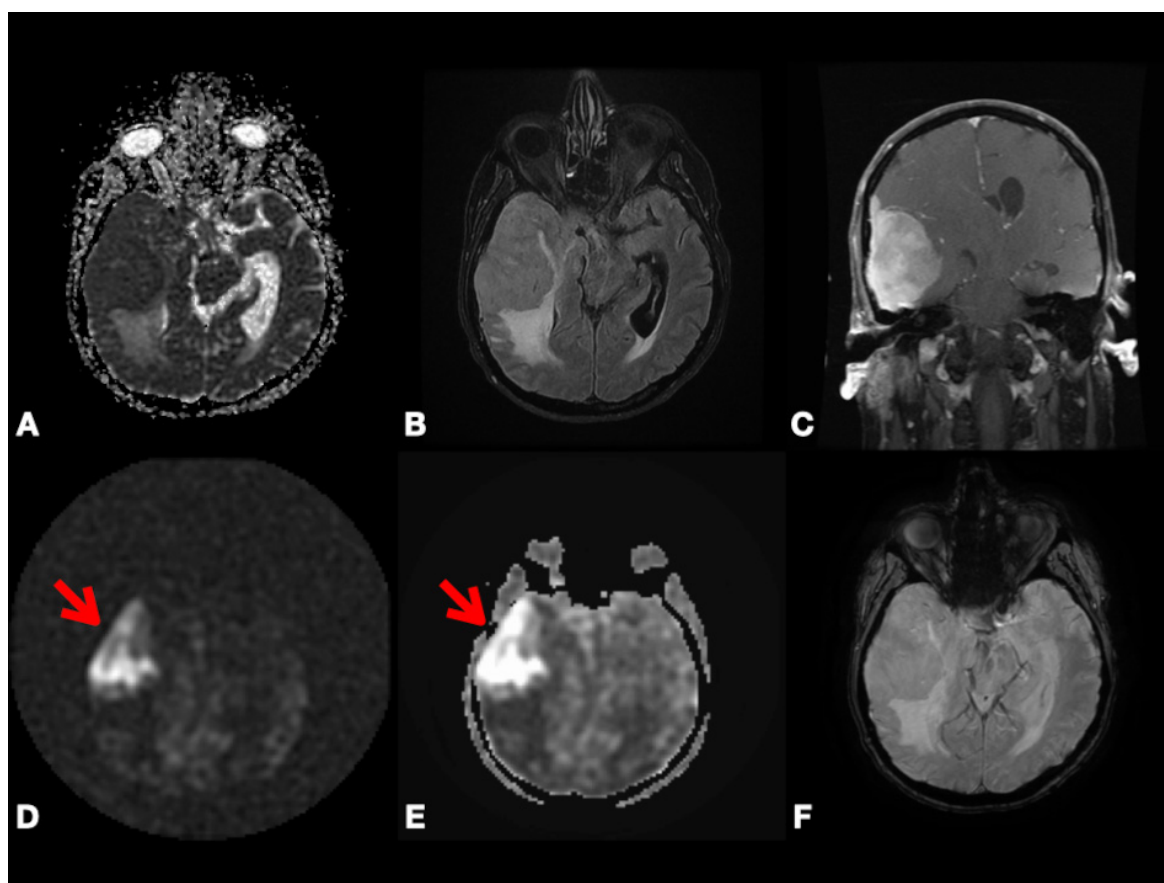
Right cerebral convexity atypical meningioma (WHO Grade II). Axial ADC map (A), axial FLAIR (B), coronal fat-suppressed post-contrast T1-weighted (C), and axial SWI (F) images depicting large avidly enhancing plaque-like non-calcified mass with dural tail, reduced diffusivity, extensive vasogenic edema and mass effect with uncus herniation and ventricular trapping. Axial pcASL source data (D) and grayscale CBF map (E) depicting marked heterogeneous hyperperfusion (red arrows). Abbreviations: ADC, Apparent diffusion coefficient; FLAIR, Fluid attenuated inversion recovery; SWI, Susceptibility weighted imaging; pcASL, Pseudo-Continuous Arterial Spin Labeling; CBF, cerebral blood flow.
